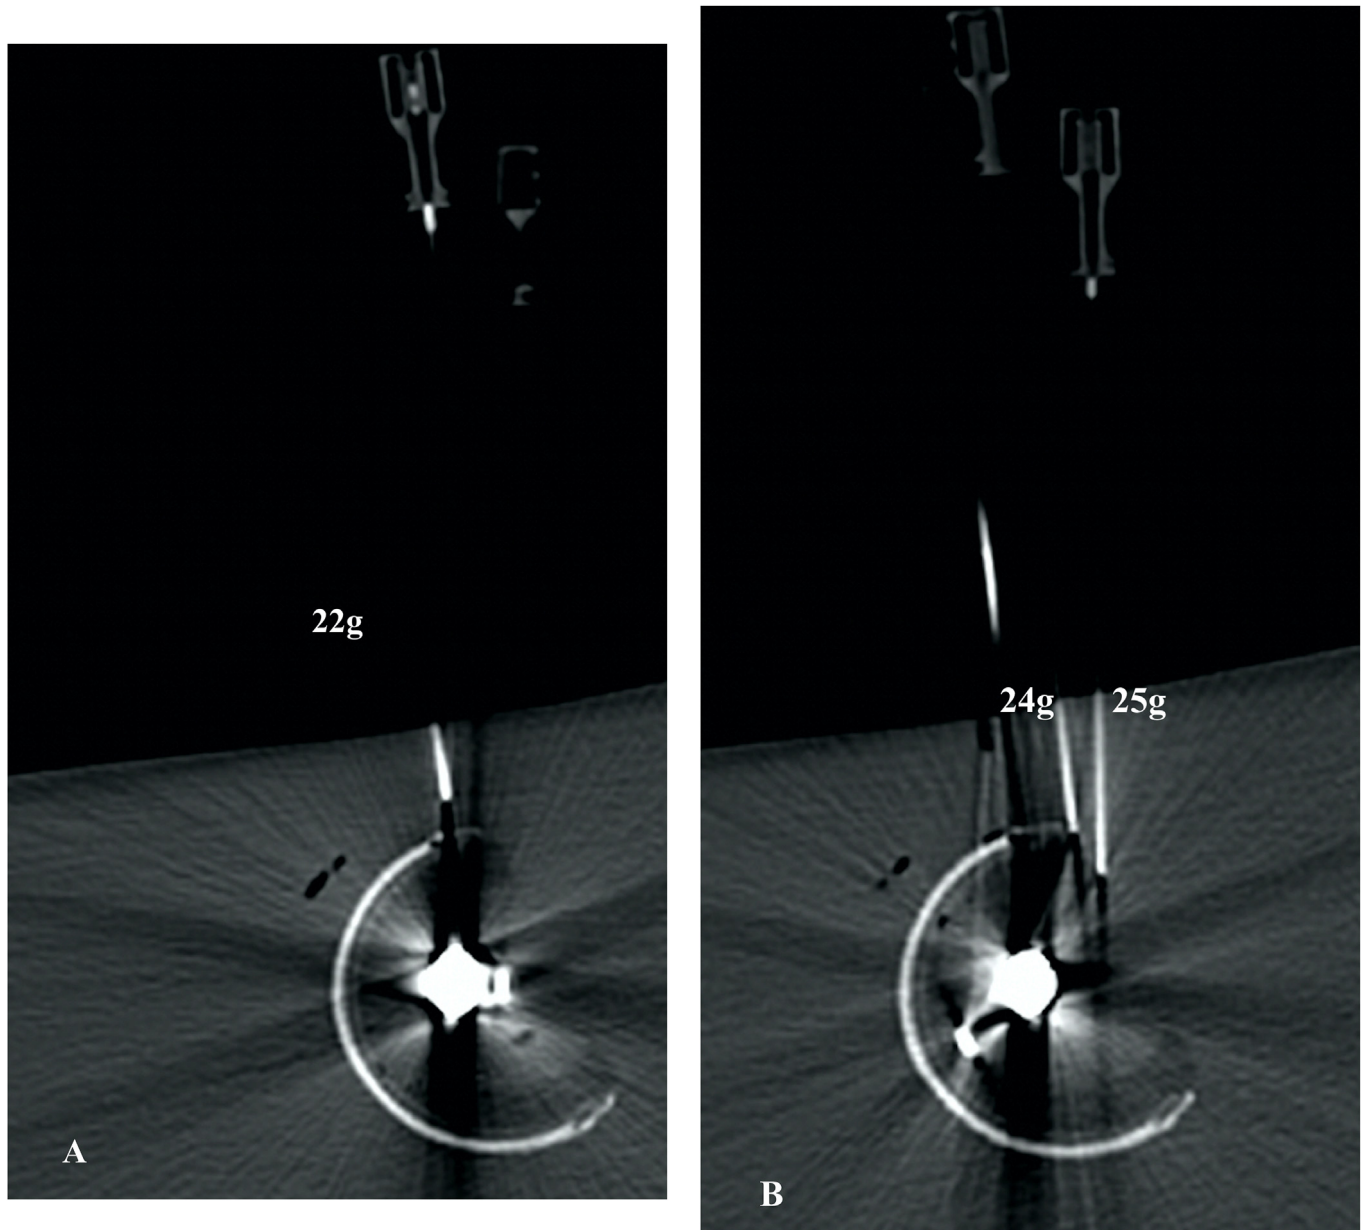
CT appearances in series 15 in Table 1. Settings were KV 140, mAs 6.5. Slice thickness 2.4 mm, DLP 12.4 mGycm (high dose). 3a shows the 22 gauge needle. 3b shows the 24 and 25 gauge needle (for the same CT settings). There are prosthesis related and needle related artefact but it does not obscure the tip of the needle.
